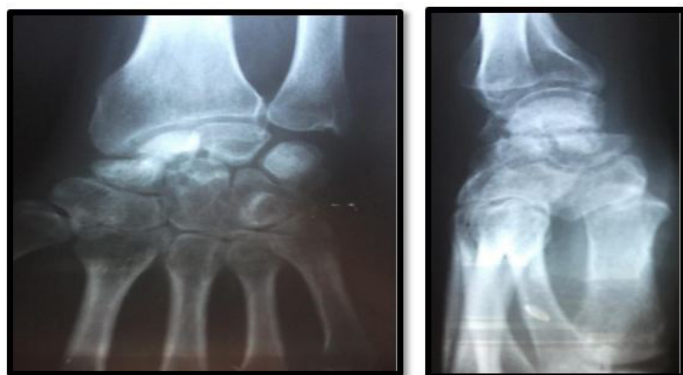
Right wrist X-Ray at 18 months: there is a non-union of the scaphoid fracture.
